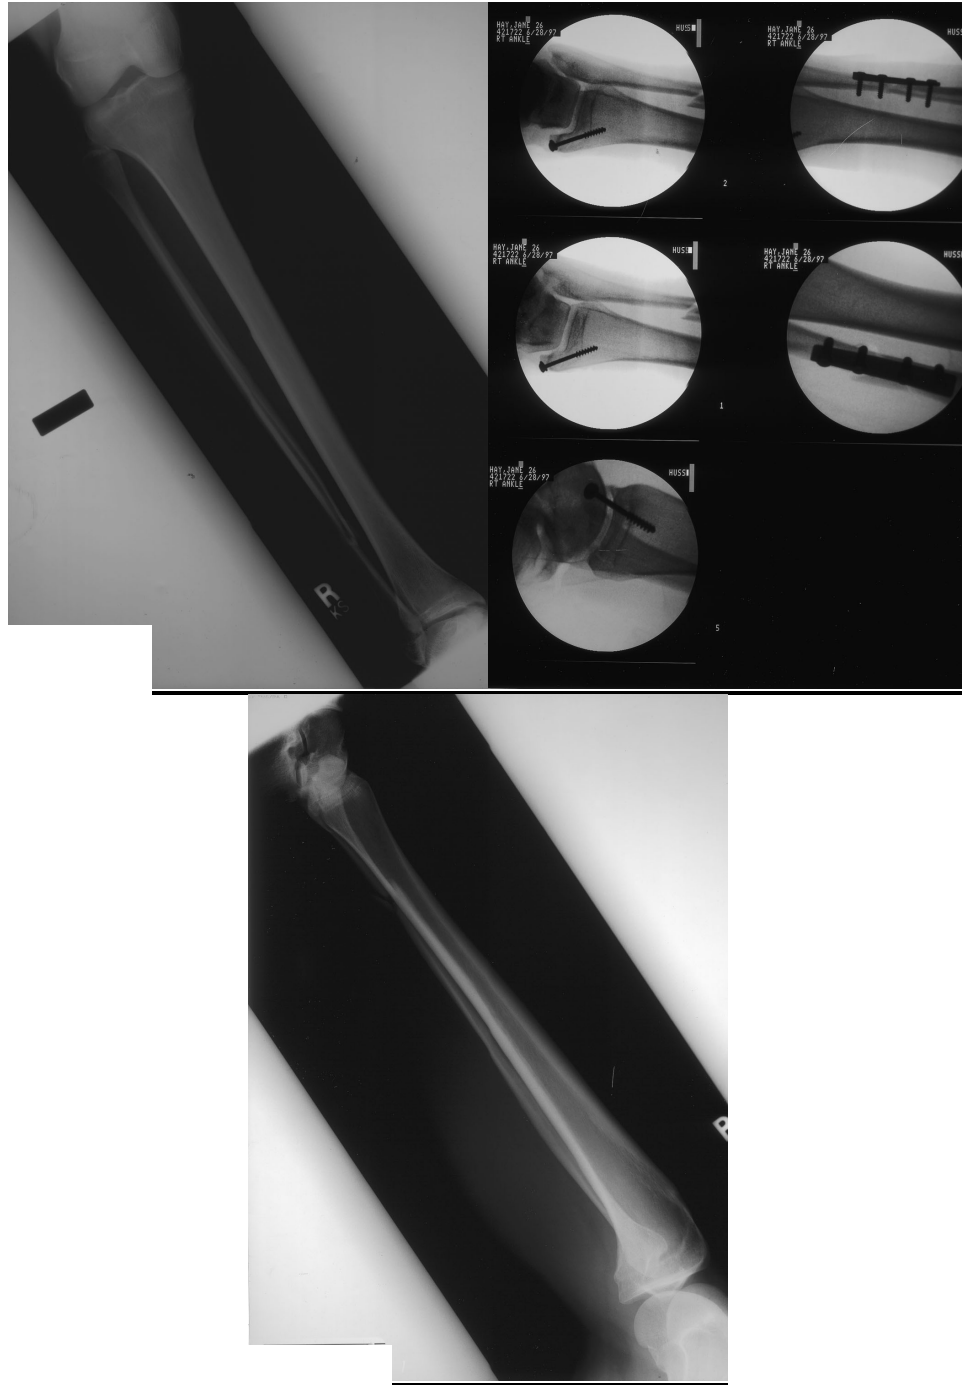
Radiographs from PWC File 6.
